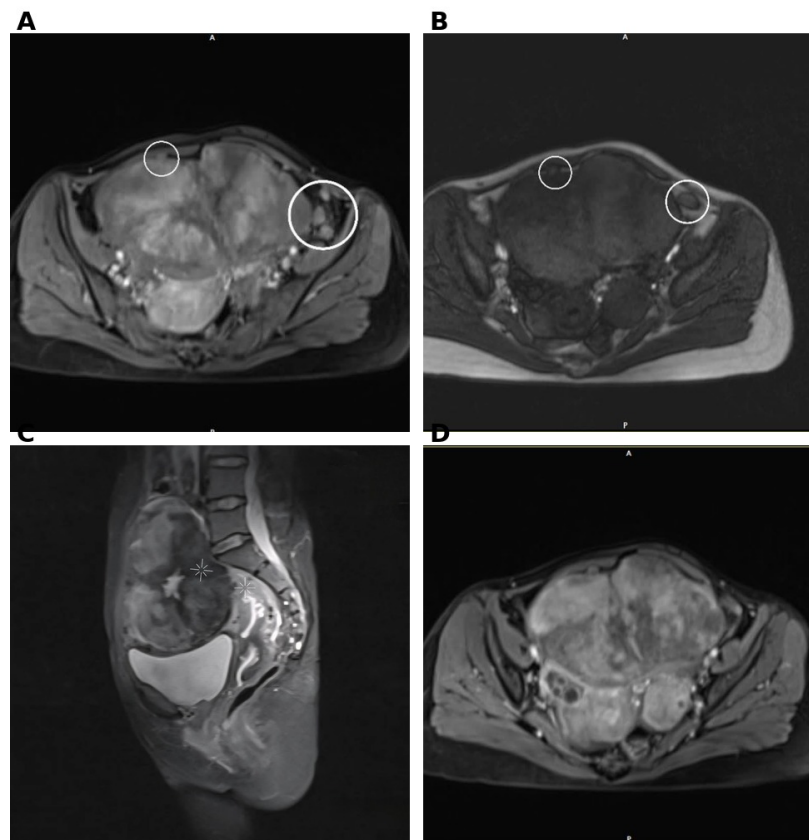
Preoperative MRI. (A) Axial image showing the large uterine mass with the “claw sign” (myometrium wrapping the lesion) and well-circumscribed omental/peritoneal nodules without ascites, classic for DPL. (B) Axial T2-weighted image showing omental nodules with low T2 signal, reflecting dense, hypocellular smooth-muscle bundles typical of leiomyoma rather than a more cellular malignant process. (C) Sagittal STIR image showing the same mass with predominantly low T2 signal and central necrosis anterior to the uterus; focal high-T2 areas raised concern for leiomyosarcoma, but the overall pattern and lack of diffusion restriction favored a degenerating leiomyoma. (D) Post-contrast image showing two enhancing bilateral pelvic masses, the larger left-sided one appearing to arise from the ovary, raising the differential of a pedunculated FIGO type 7 leiomyoma.
